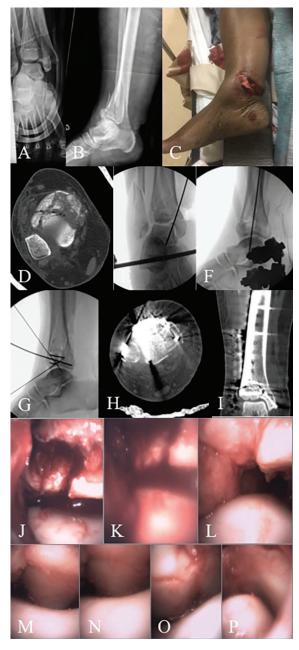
57-year-old female in a motor vehicle collision who sustained a Gustilo-Anderson type 3A open right pilon fracture. Injury mortise (A) and lateral (B) ankle x-rays. Clinical photo of medial, transverse, tension failure wound (C) in the trauma bay. Pre-operative axial (D) computed tomography scan demonstrating significant anterior and medial comminution. Intra-operative fluoroscopy mortise (E) and lateral (F) images during the initial debridement, irrigation, and spanning external fixation demonstrating overall restoration of length, alignment, and rotation. Lateral (G) intra-operative fluoroscopy at the time of definitive fixation with provisional stabilization and reconstruction of the articular block. Post-operative axial (H) and coronal (I) computed tomography demonstrating reduction of the articular block. Intra-operative view of the lateral joint pre reduction (J) to post reduction (K, L). Intra-operative view of the joint post reduction progressing from the central joint space to the medial joint space (M, N, O, P) confirming accurate medial reduction without needing to re-open the traumatic medial wound.
